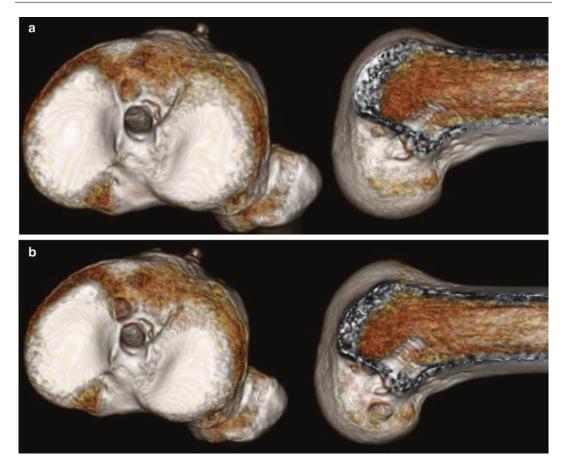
a Three-dimensional computed tomography of the knee showing very malpositioned tibia and femoral tunnels. Tibia tunnel is placed too posteriorly and femoral tunnel is placed too anteriorly. b Three-dimensional computed tomography of the knee showing entirely new tunnels created in revision anterior cruciate ligament reconstruction, bypassing the existing tunnels
